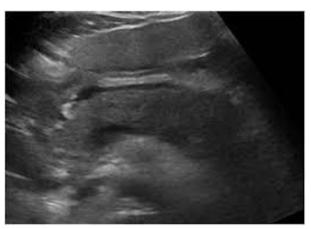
Ultrasound Scan in Acute pancreatitis
